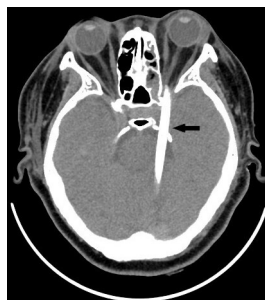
CT scan shows an intracranial rod-shaped foreign body. Intracerebral haemorrhage is not present (arrow).
